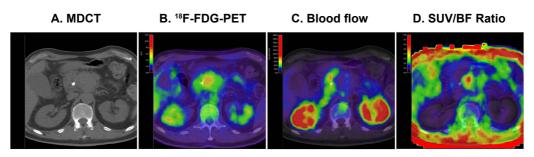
A 64-year old male with a history of abdominal pain and significant weight loss developed jaundice. MDCT showed a tumor in the head of the pancreas (A), and ¹⁸F-FDG uptake was observed in PET (B). Reduced BF of the tumor was detected compared to the non-tumoral part of the pancreas in ¹⁵O-H₂O-PET/CT (C). Further, SUV/BF ratio was high, 0.58, as a sign of aggressive disease (D). At operation, radical resection was not possible and the biopsy of the tumor revealed adenocarcinoma gradus 2. The patient died three months after diagnosis.
